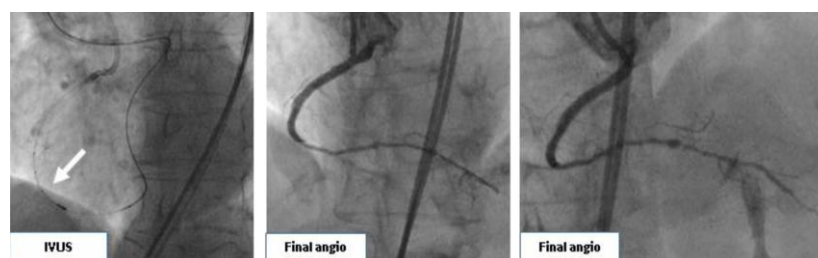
Final angio result after intravascular ultrasound (IVUS) optimization.
